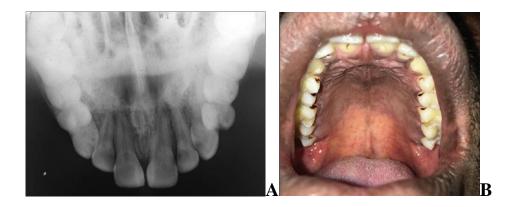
A-Occlusal radiograph showing round/heart shape symmetrical radiolucency. B-Solitary oval swelling in the midline of hard palate. (Rangaswamy et al, 2018)
